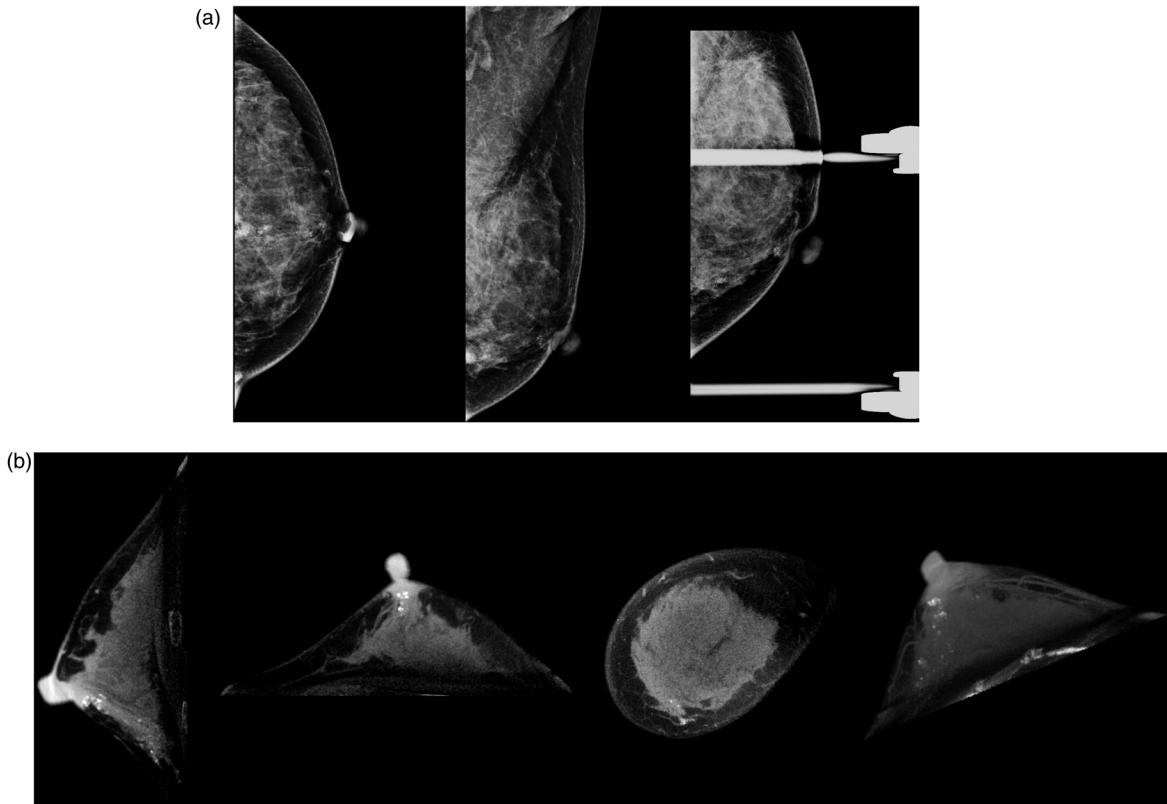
Example of a segmental fine pleomorphic calcifications cluster detected on mammograms and breast CBCT images. (a) Craniocaudal, mediolateral oblique, and magnified views of mammograms; (b) sagittal, axial, and coronal views and 3D-MIP of non-enhanced CBCT images at a slice thickness of 1 mm (b). 3D-MIP, three-dimensional maximum-intensity projection; CBCT, cone-beam computed tomography.
